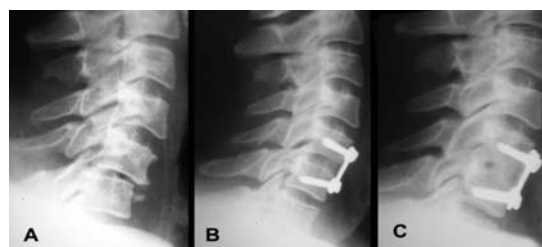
Patient number 5. (A) C1-type, Frankel E injury at C5-C6. (B) Reduction and arthrodesis through anterior access. (C) X-ray image one year after surgery showing arthrodesis of vertebral bodies and posterior elements.
